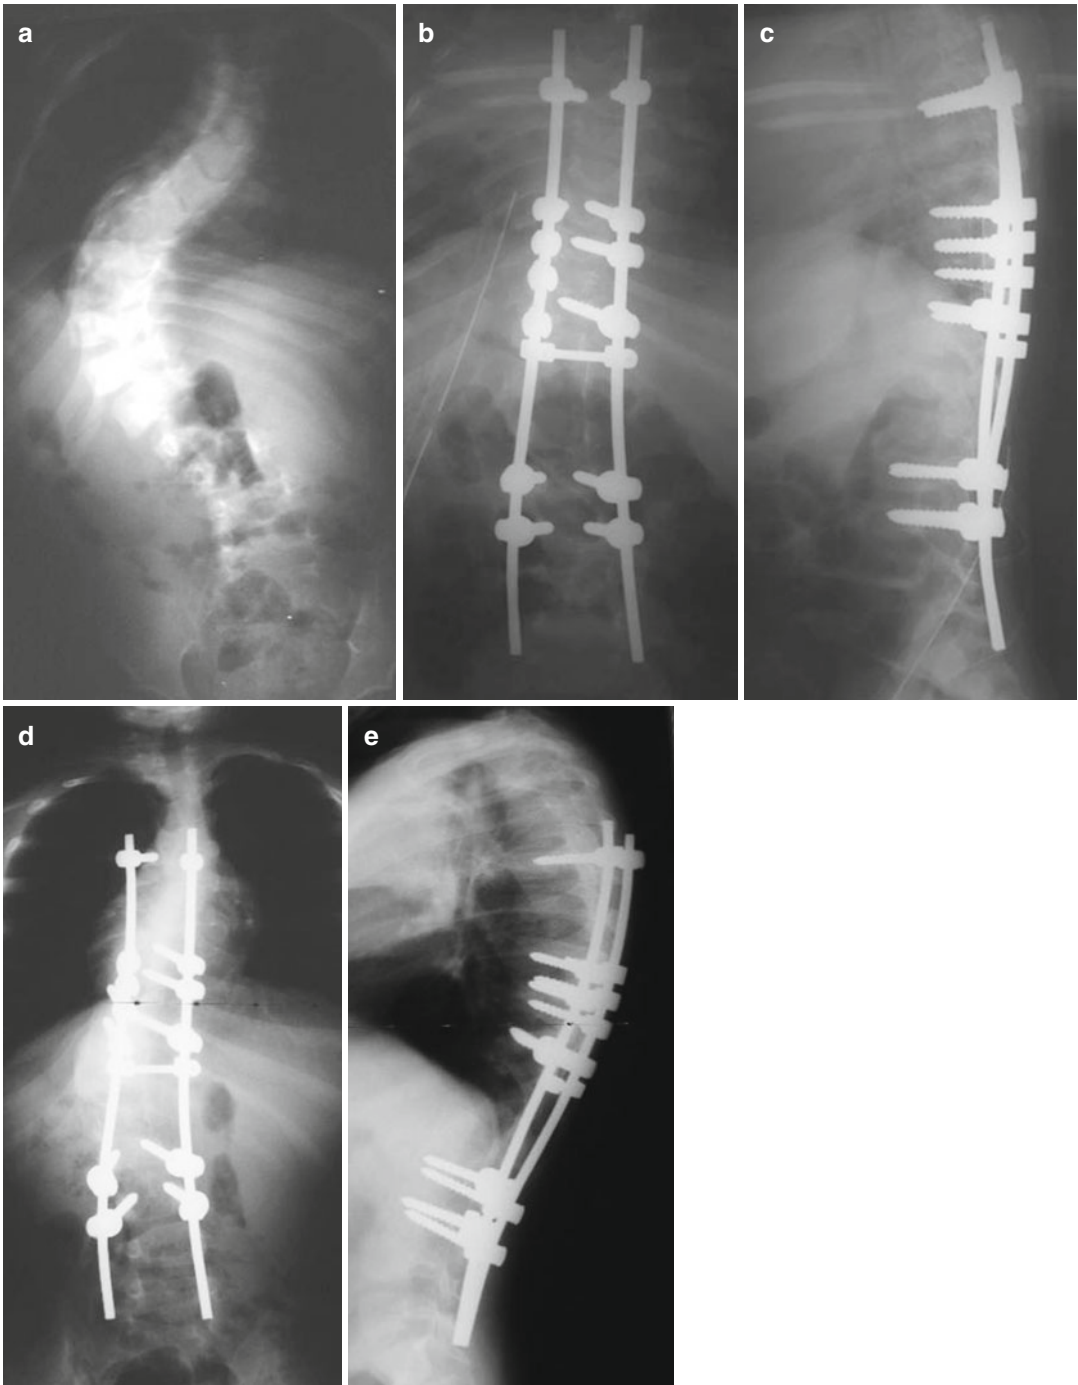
(a–i) Preoperative (a), 6-week postoperative (b, c), and 5-year postoperative radiographs (d, e). Clinical photographs preoperatively (f, g) and 5 years postoperatively (h, i)
